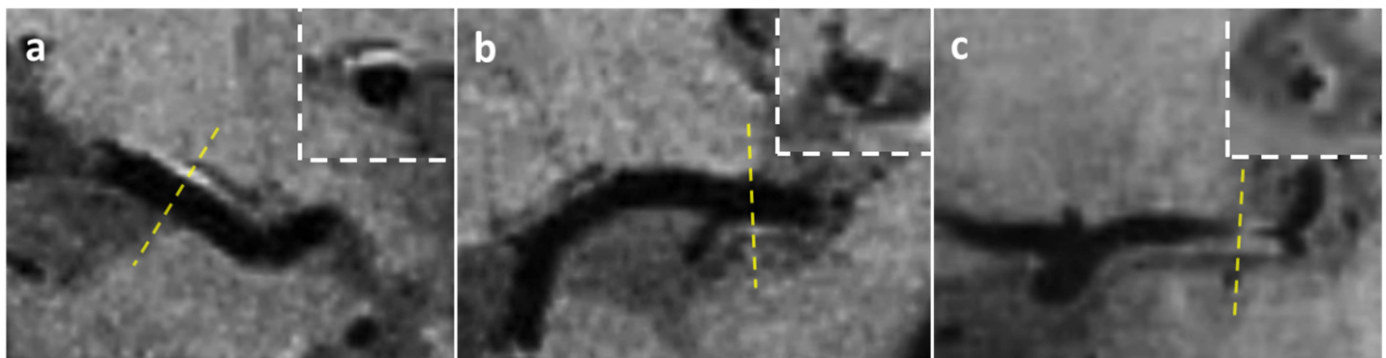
Categorize plaque distribution on contrast enhanced dark blood MRI imaging. (a) Superior plaque; (b) Inferior plaque; (c) Plaque involving both superior and superior wall
